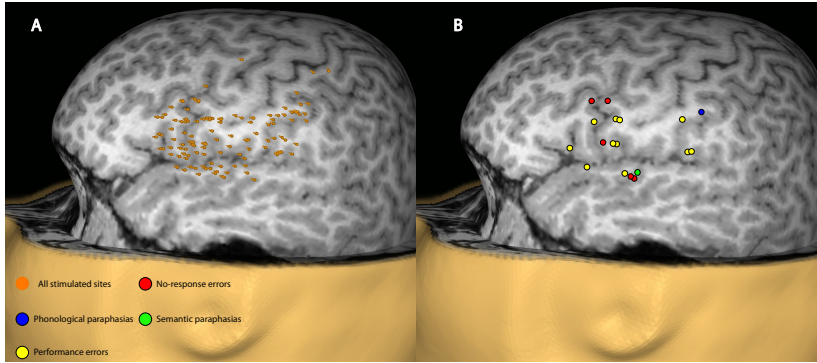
Results of an nTMS speech mapping shown over the 3-D MRI reconstruction of one subject's head. A: All the stimulated cortical sites. B: The cortical sites where speech errors were induced.
